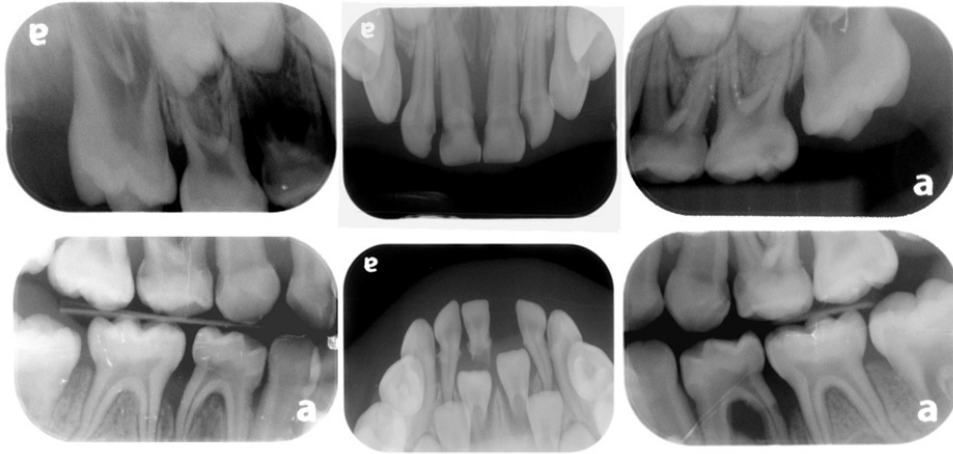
Radiographs were taken when patient was 5 years old (8/24/2017). Radiographic findings: Calculus deposition on anterior teeth and molars region. Generalized alveolar bone destruction and angular bone defect of #A, I, L, S, #O missing, #D, E, F, G caries was noted.
